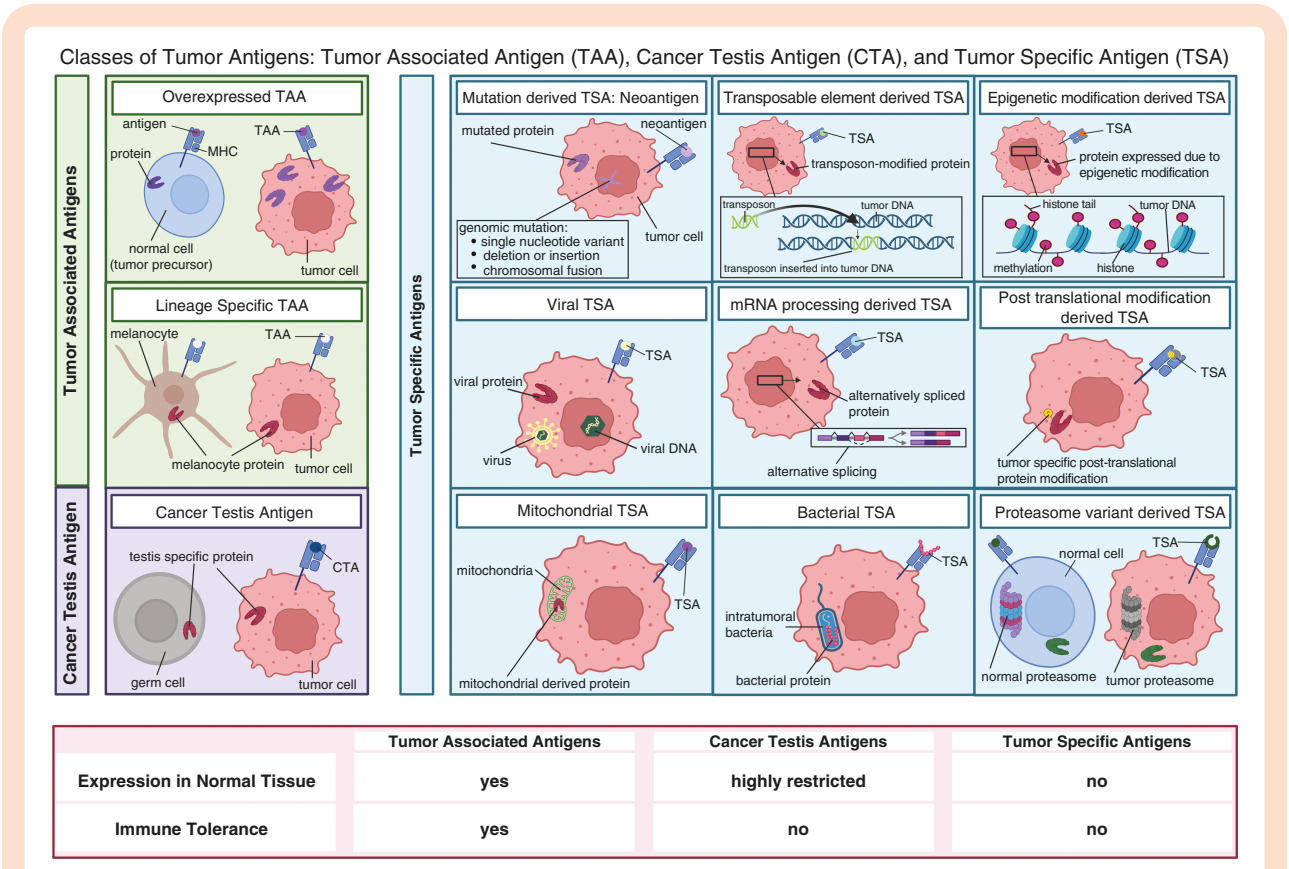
Tumor antigens can be ascribed to three classes: tumor-associated antigen (TAA), cancer testis antigen (CTA), and tumor-specific antigen (TSA). TAAs are self-antigens that are present in tumor cells; they include the overexpressed and the lineage specific. While the proteins from which CTAs derive are present in male germline cells and trophoblasts, antigen expression is mostly isolated to tumors. TSAs that occur secondary to mutations, like single-nucleotide variants (SNVs), insertions or deletions of amino acids (INDELs), or gene fusions, are called neoantigens. Myriad other causes of TSAs may include transposable elements, epigenetic modifications, viruses, altered mRNA processing (such as alternative splicing), post-translational modifications, mutations in mitochondrial DNA, bacterial proteins, and proteasome variants. The classes of TAs vary in their levels of expression in non-tumor tissue and in the degree of immune tolerance, factors that impact off-target effects and efficacy, respectively, of antigen-focused therapy for cancer.
